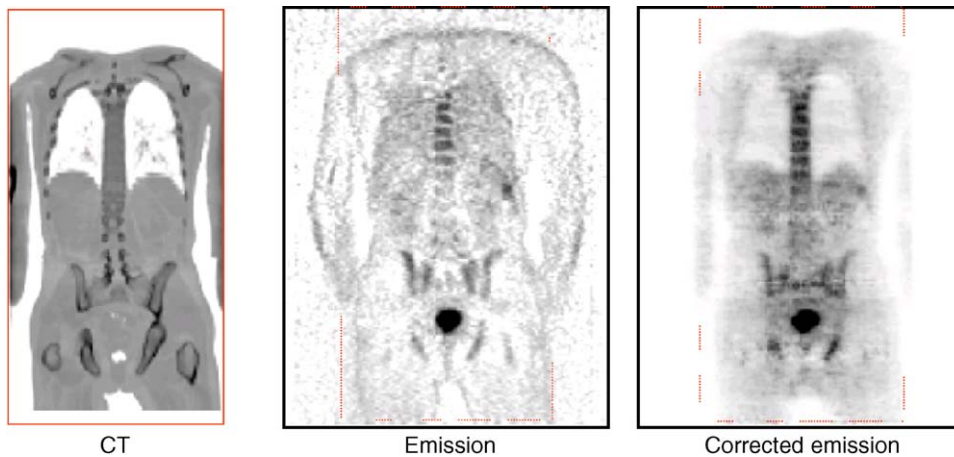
In large patients and patients with arms down the limited transverse FOV (50 cm) of the CT may cause truncation of the anatomy images (left). Truncation is usually not observed on the emission data (middle) with the 60 cm FOV of the PET. Using truncated CT images for attenuation correction introduces a masking effect onto the corrected PET images (right).
